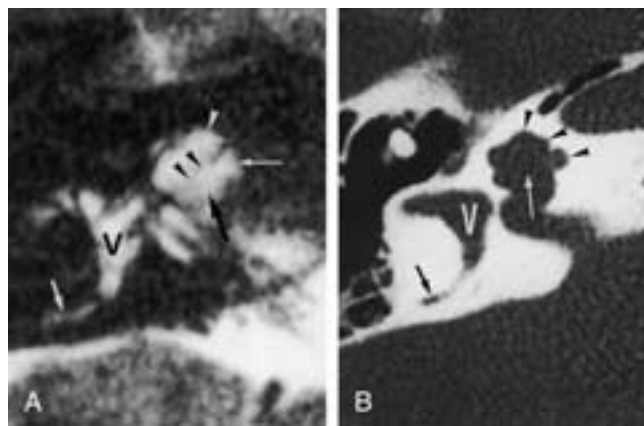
Mondini malformation. A, Axial 0.7 mm thick gradient-echo T2-weighted image (3DFT-CISS) through the apical and second turns of the right cochlea. There is a defect (*black arrowheads*) in the bony wall between the apical turn (*white arrowhead*) and second turn (*long white arrow*) of the cochlea. The bony wall between the cochlea and IAC is absent (*large black arrow*). Common crus (*small white arrow*), vestibule (V). B, Corresponding axial CT image through the right cochlea. The modiolus is absent (*long white arrow*), and the bony barrier between the IAC and the cochlea is absent. The apical and second turns of the cochlea can still be outlined on the surface of the cochlea (*black arrowheads*), but the separation between the two turns inside the cochlea cannot be recognized. Absence of the osseous spiral lamina of the middle and apical turns results in a scala communis cochleae. Posterior semicircular canal (*small black arrow*), vestibule (V).
